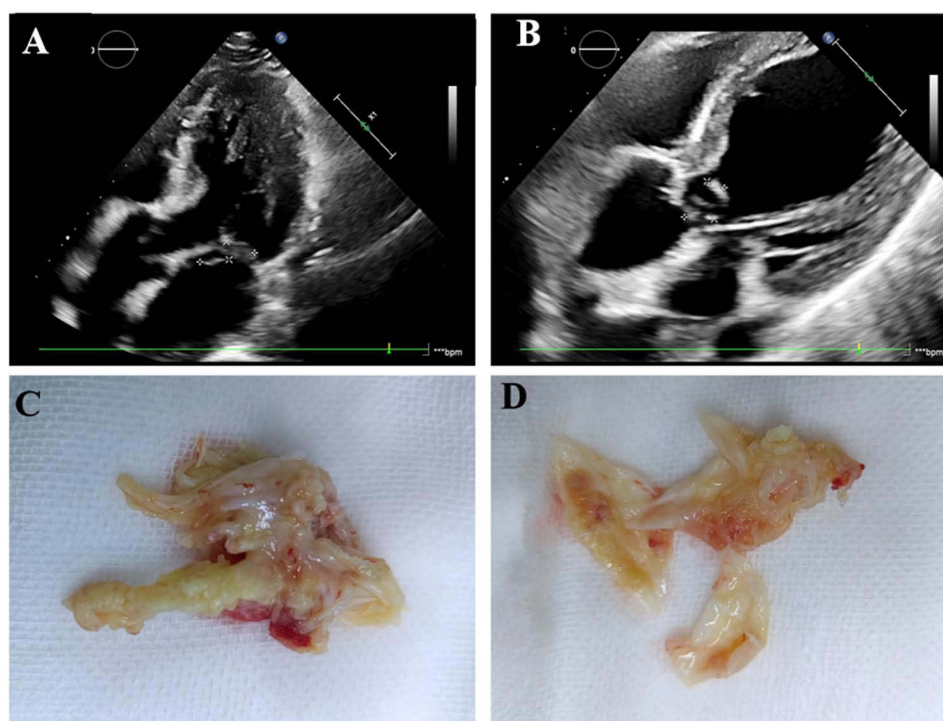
The ultrasound images of mitral and aortic valves (A and B). The surgical resection tissues of the mitral valve and the aortic valve (C and D).
